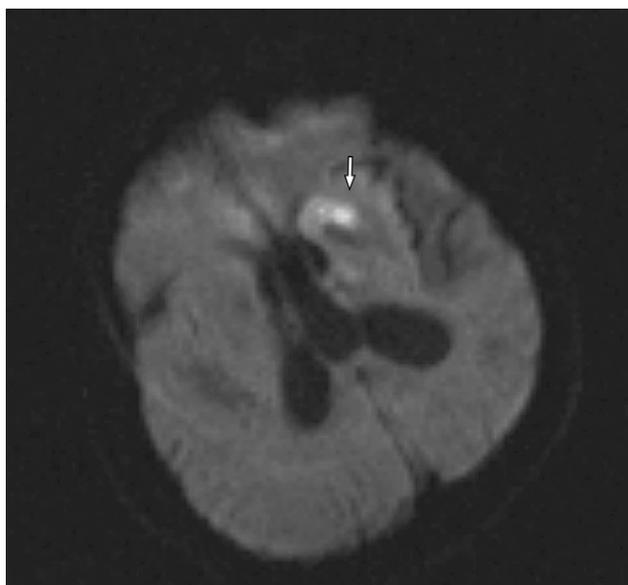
MRI of the patient's brain revealed the presence of small hyperintense signals involving the left basal ganglion and thalamus on diffusion-weighted sequences.
